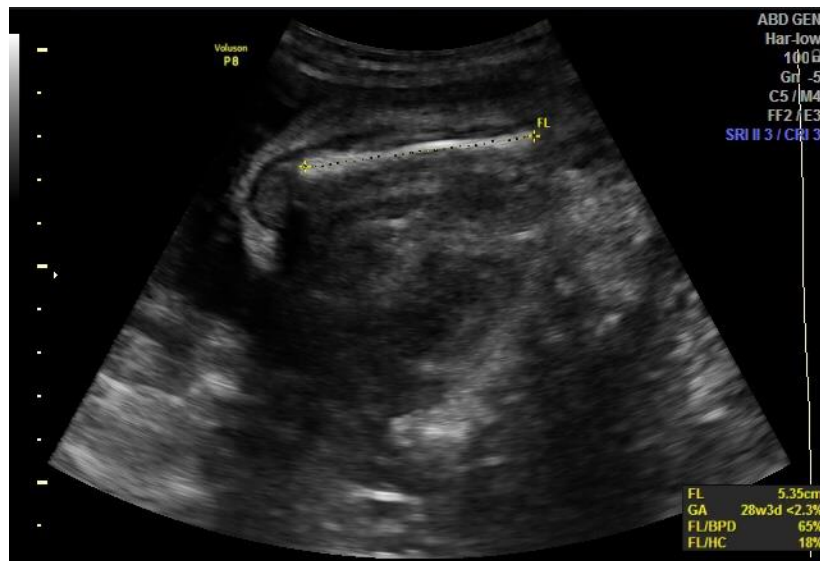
Two-dimensional B-mode grayscale ultrasound images show scalp edema and subcutaneous edema in the lower limb.
